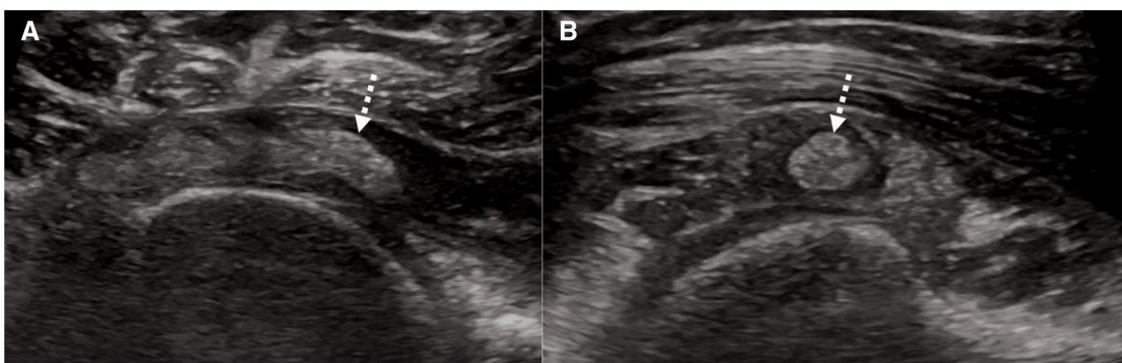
Ultrasound images of the shoulder showing longitudinal (A) and transverse (B) images of the subscapularis tendon showing calcium extension (dashed arrow) from the tendon to its corresponding muscle belly in keeping with intramuscular migration of calcium.
